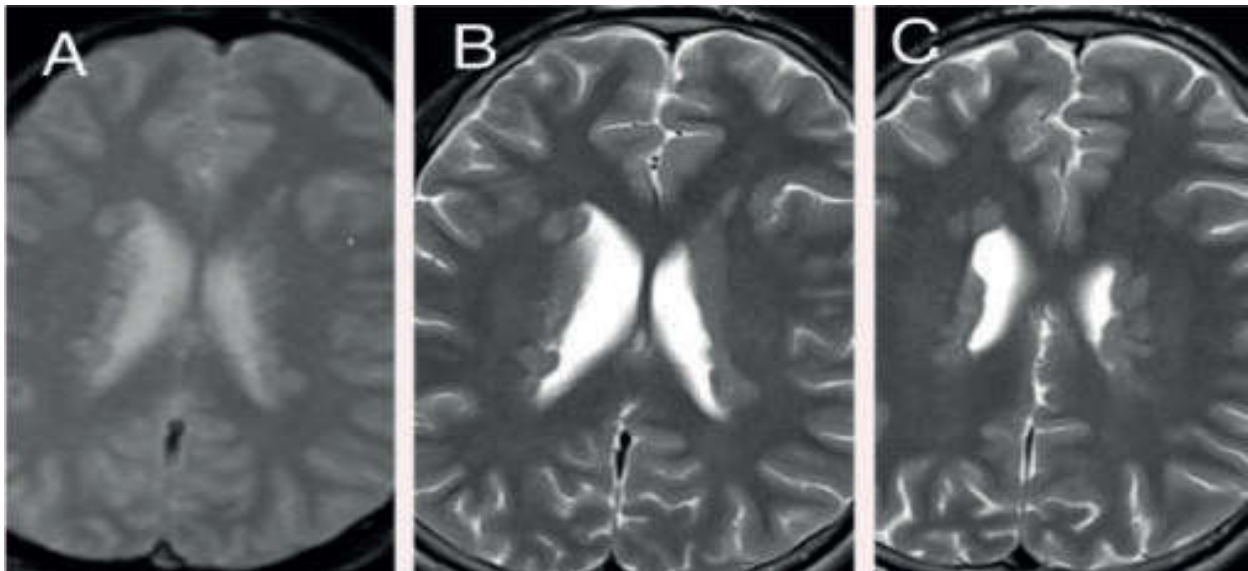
MRI of brain showing nodularity of the ependymal surface of the lateral ventricles giving it a 'lumpy bumpy' appearance as shown in A,B&C.
